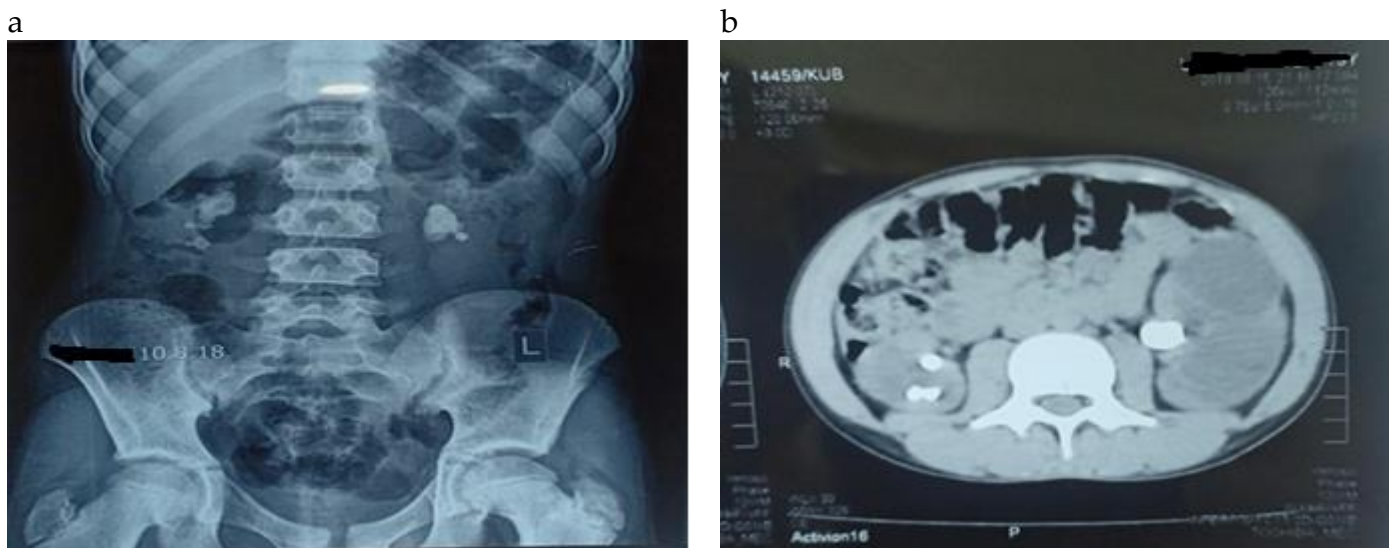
X-Ray (a) and CT KUB (b) of the 13-years-old child showing bilateral stones with left hydronephrosis
